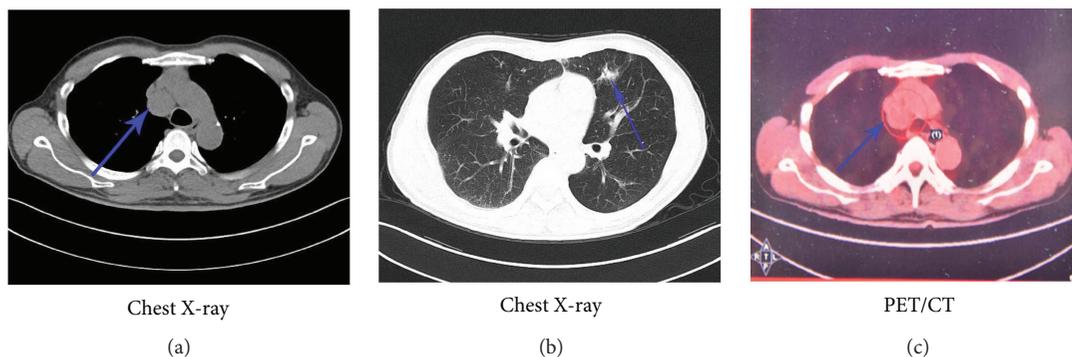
Clinical imaging findings of this GS patient. (a) An anterior mediastinal mass (2.8 cm) in chest X-ray (blue arrow). (b) Signs of pneumonia in chest X-ray (blue arrow) when first hospitalized. (c) Lesion showed via PET/CT (blue arrow).
